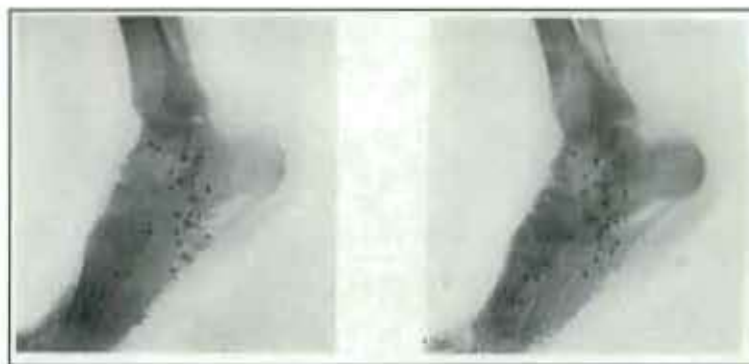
An early 1900's X-ray stereogram of a gunshot wound in the foot (Judge, 1926)
